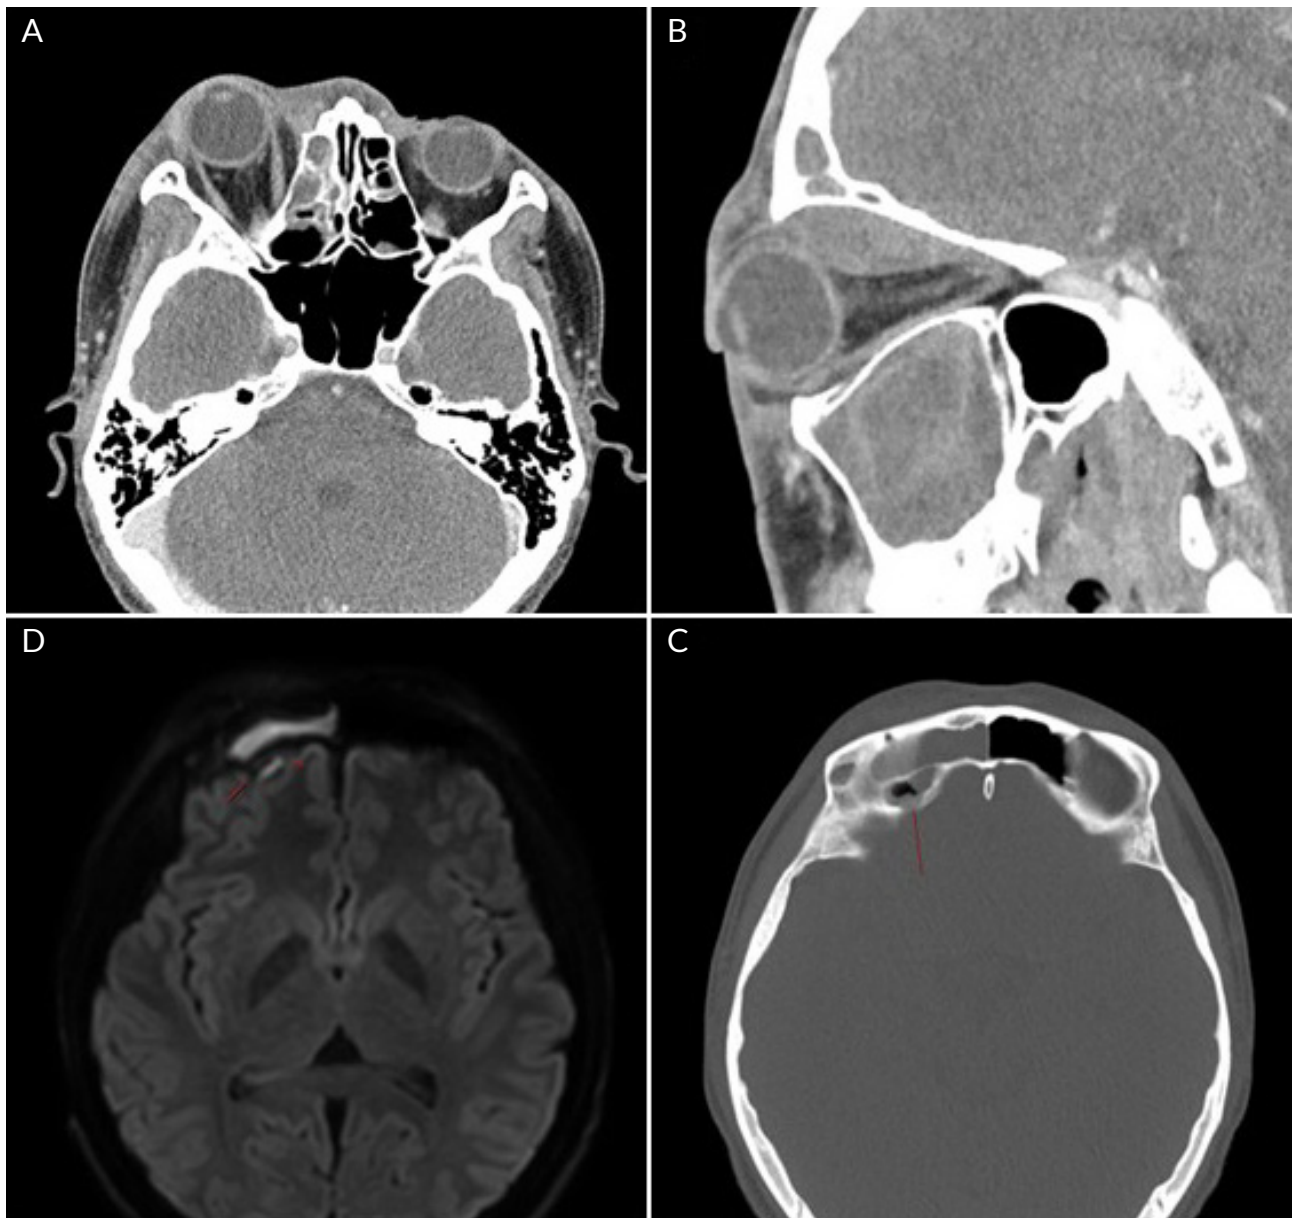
Representative images from axial and sagittal and bone setting images of post contrast CT (A, B, C) and a B-1000 image of diffusion weighted imaging brain magnetic resonance imaging (D), Clockwise from top left: A. Proptosis of right eye, B. Abscess pocket in right superior orbit, Acute sinusitis in right frontal and maxillary sinuses, C. Erosion in inner wall of right frontal sinus, D. Minimal epidural abscess in right frontal convexity.
